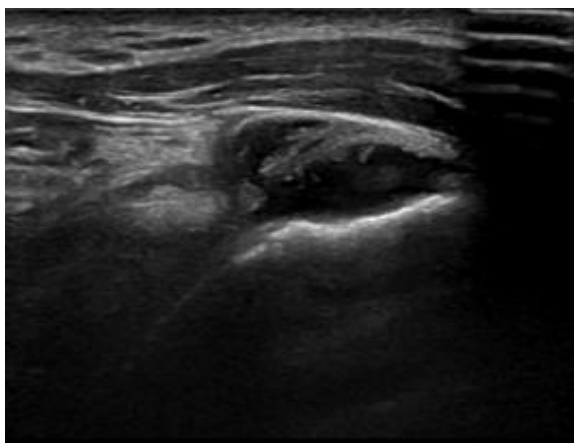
Longitudinal ultrasound shows full-thickness mid-fibre tear of the supraspinatus tendon with tendon discontinuity. The gap is filled with anechoic fluid with fibres retracted.
